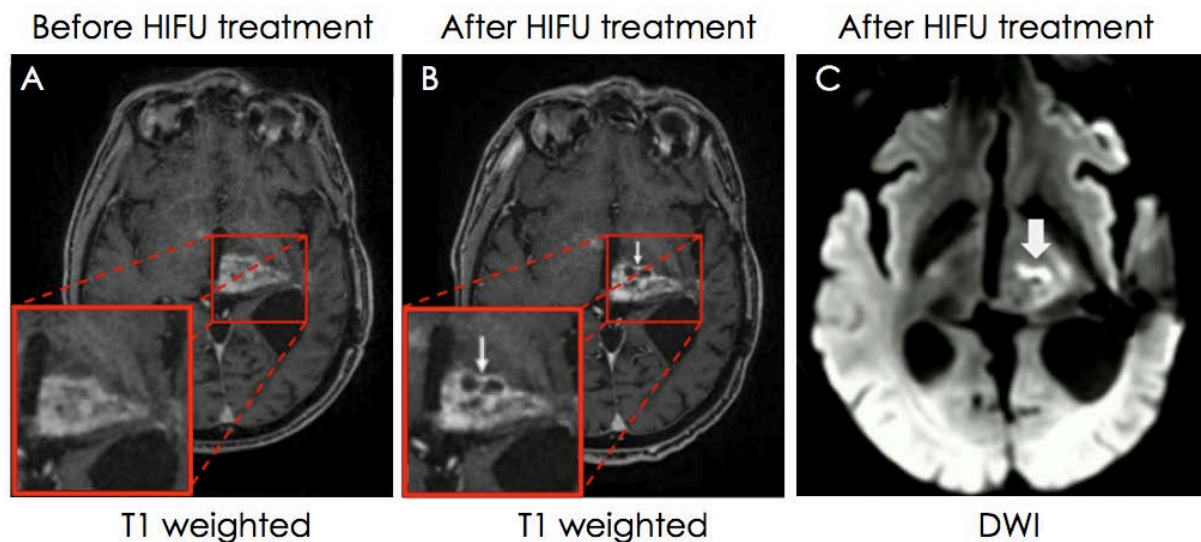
Pre- and post-interventional MR findings of a brain tumor in living patient. (A, B) T1-weighted image depicts a contrast-enhanced tumor with a progressive necrotic center in the post-interventional follow-up after 5 days. (C) Diffusion weight imaging (DWI) performed 30 min after intervention revealed significant damage to the sonicated tumor tissue. Over the 25 sonications, 17 sonications reached ablative temperatures  $>55^{\circ}\text{C}$  with a maximum of  $65^{\circ}\text{C}$ . *Figure adapted from (Coluccia et al. 2014).*
